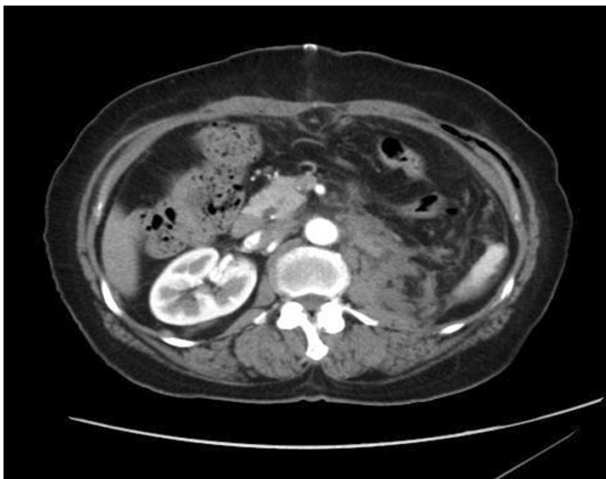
Postoperative abdominal computed tomography scan (case 1) shows a stump of the left renal artery and almost full resorption of the hematoma in the retroperitoneal space.
